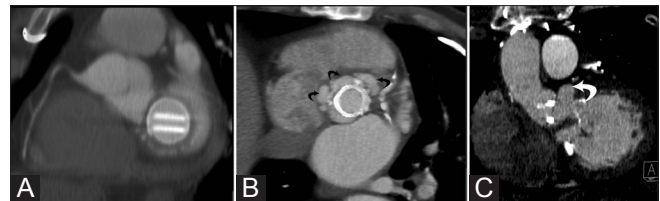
(A–C): Prosthetic valve. Short-axis reconstructed CT image (A) shows a tilting disk valve in the mitral position, which is well seated. Short-axis reconstructed CT image (B) shows multiple contrast-filling aortic root abscesses (arrows) surrounding mechanical aortic valve. Coronal-oblique reconstructed CT image (C) in a patient with bioprosthetic aortic valve shows dehiscent valve and pseudoaneurysm (arrow) extending from the left sinus
